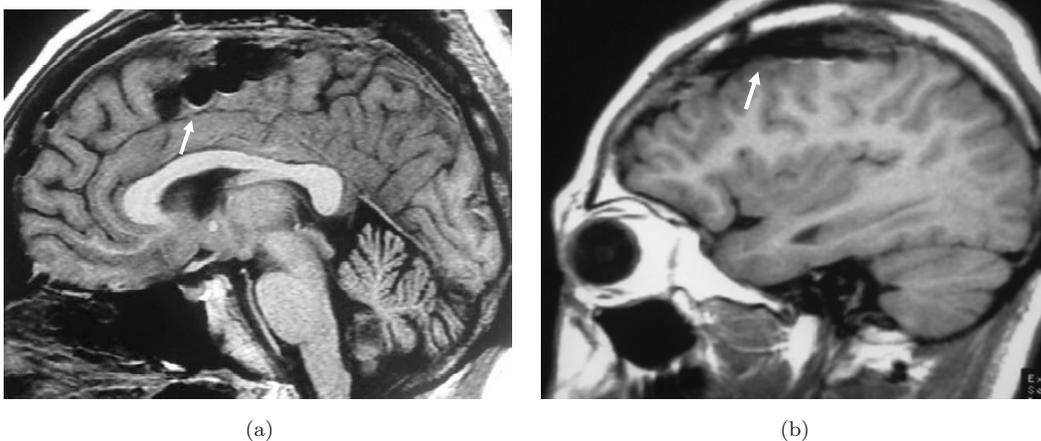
MRI showing definite therapeutic 4 contact electrode position. 3(a) shows Case 1 electrode within the supplementary motor area. 3(b) shows Case 2 electrode position within the motor cortex. The permanent 4 contact electrode is implanted using the diagnostic grid that is removed in the same surgical procedure as a guide. The chronic stimulation contacts must overlap the epileptic focus area. White arrows indicate pair of stimulated contacts in both patients.
